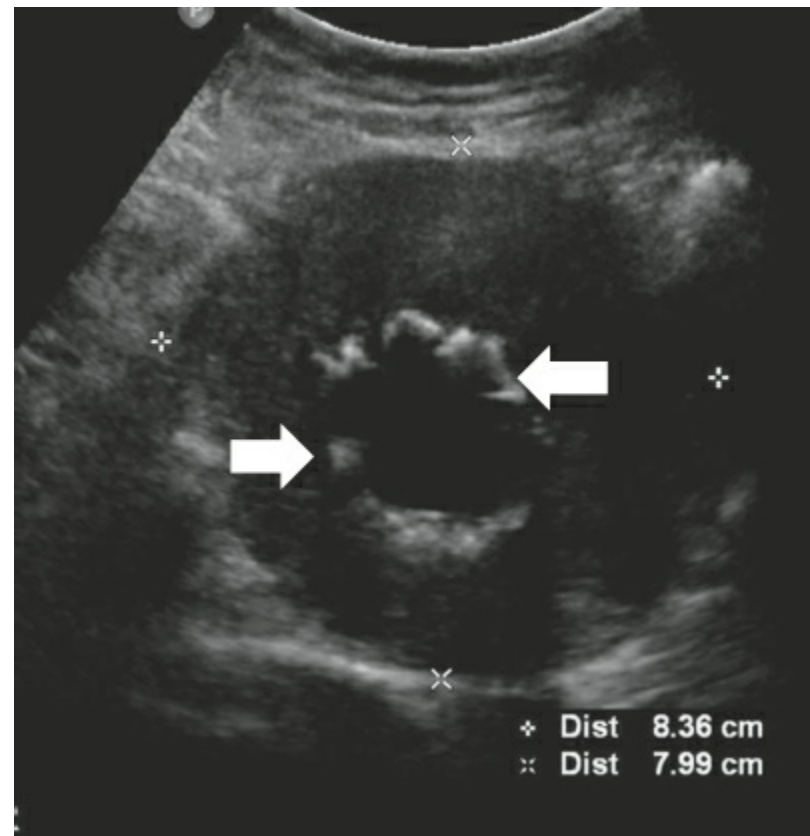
Ultrasound examination of an aortic stent graft. The aortic stent graft (*arrows*) is visible within the lumen of the residual aneurysm sac measuring 8.36 cm × 7.99 cm.
